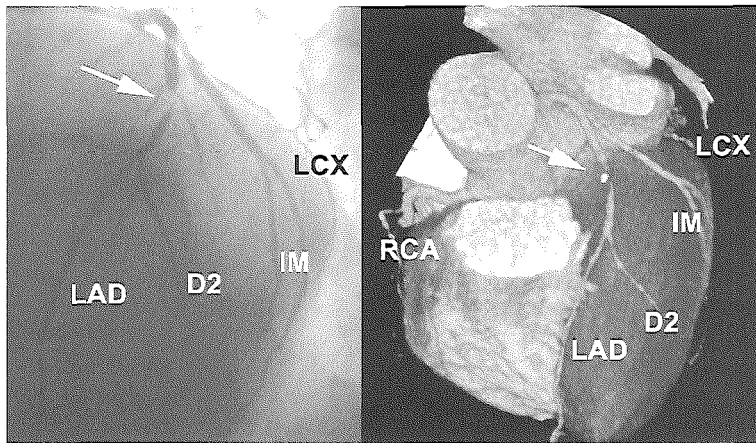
Conventional and multislice spiral CT (MSCT) coronary angiogram (3D volume rendered) of a patient with a stenotic coronary lesion in the mid left anterior descending branch (LAD), just distal from the small first diagonal branch. Also the calcified contents of the plaque are visualized on the MSCT angiogram. The left circumflex coronary artery (LCX), right coronary artery (RCA), second diagonal branch (D2) and intermediate branch (IM) can also be appreciated.
